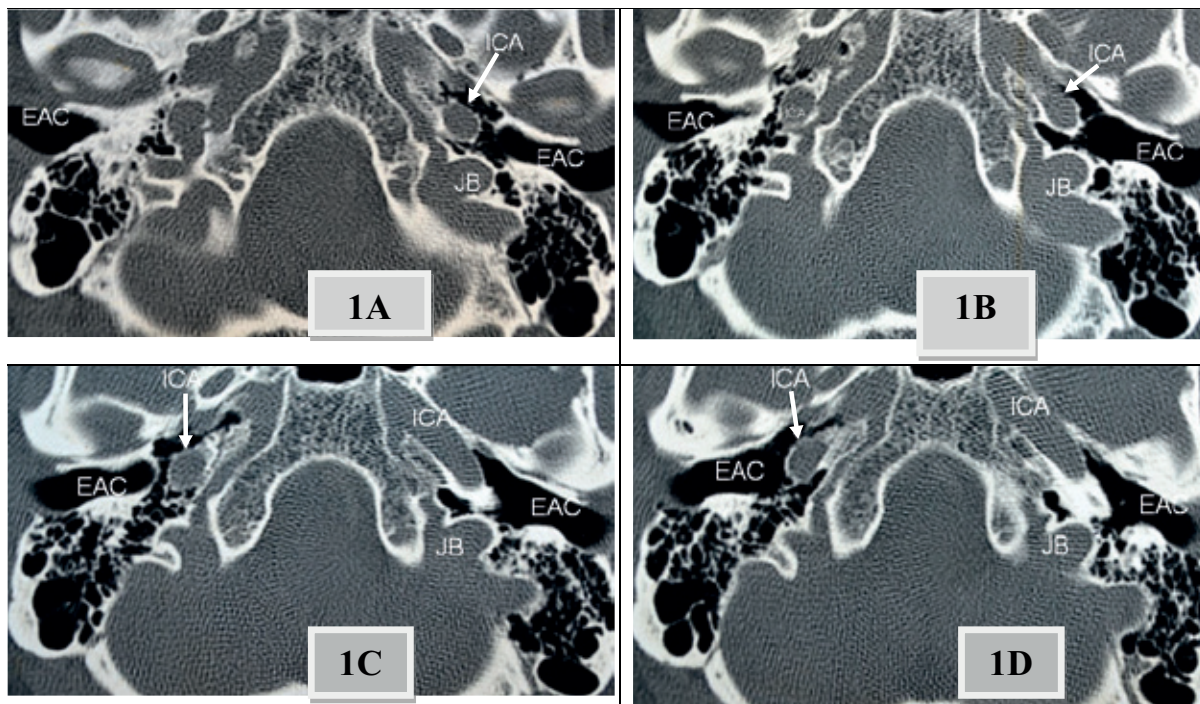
Left unilateral high jugular bulb was demonstrated in the temporal bone HRCTs. Bilateral mastoid pneumatization was in high grade (+++) and there was bilateral ICA dehiscence. 1A. Left ICA dehiscence (white arrow) was shown in the axial section of the temporal bone HRCT. 1B. Left ICA dehiscence (white arrow) was shown in the axial section of the temporal bone HRCT. 1C. Right ICA dehiscence (white arrow) was shown in the axial section of temporal bone HRCT. 1D. Right ICA dehiscence (white arrow) was shown in the axial section of the temporal bone HRCT. EAC – external acoustic canal, JB – jugular bulb, ICA – internal carotid artery.
